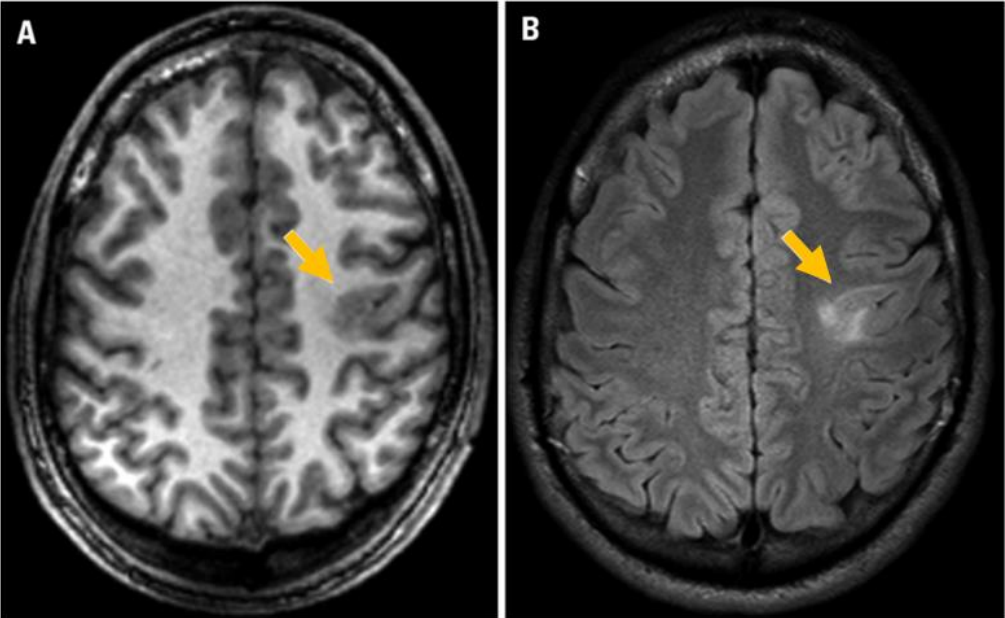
A) MRI scan of a patient with focal cortical dysplasia (T1 weighted), and B) FLAIR image of the same patient; the arrows indicate the area of question, specifically the area of mild cortical thickening [6].
